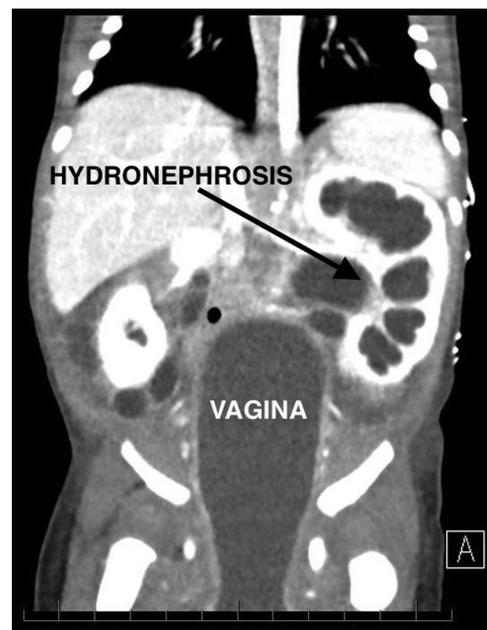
Reaccumulation of hydrocolpos and hydronephrosis on computed tomography scan.
